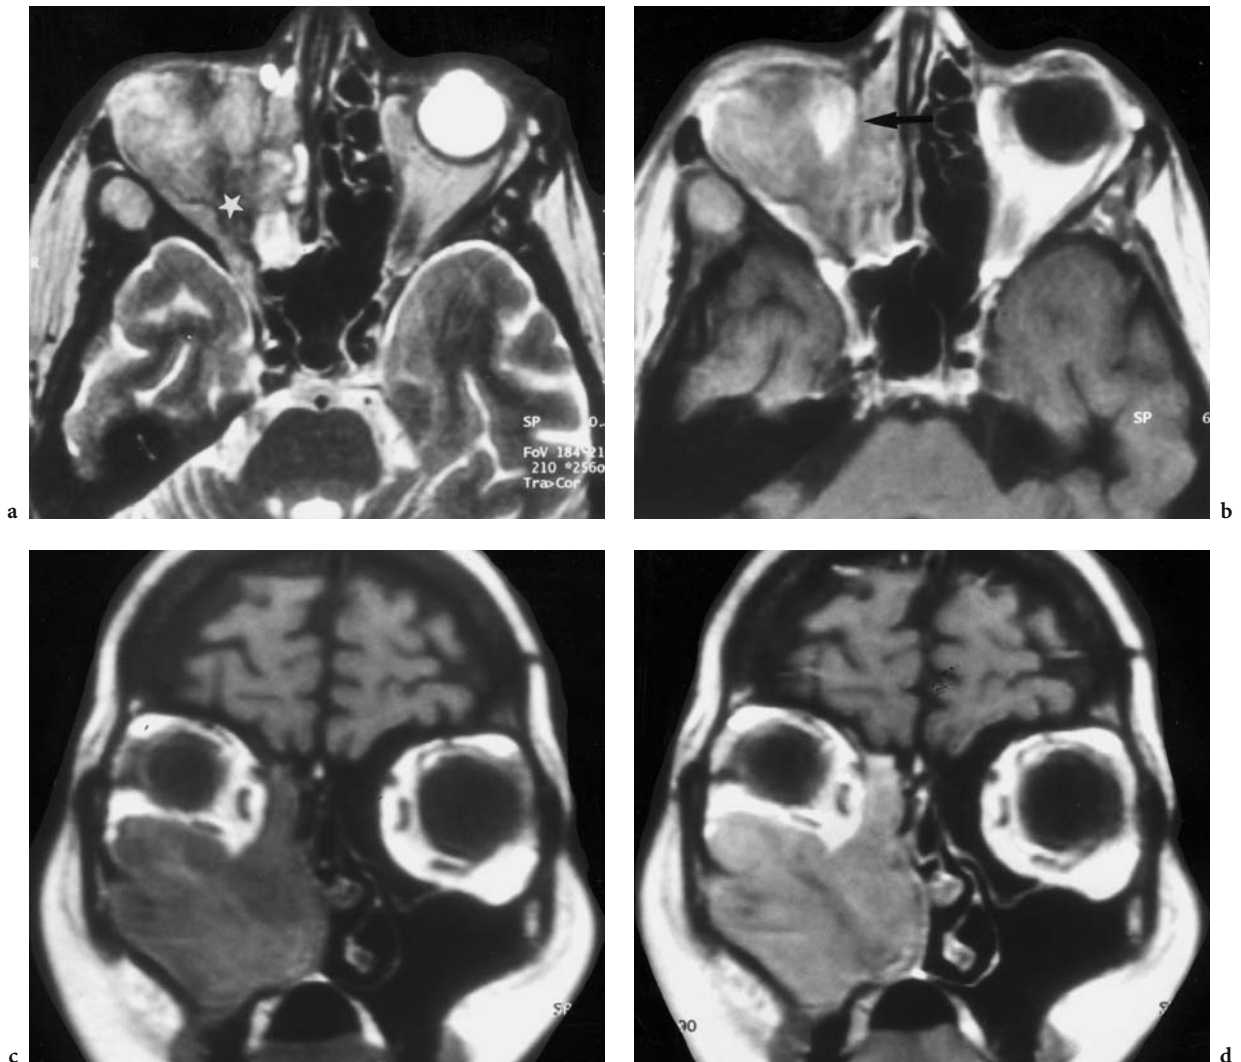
A 37-year-old woman with previously operated primary melanoma of the maxillary sinus, presenting with swelling of the right eye. Diagnosis: intraorbital expansion of the maxillary sinus melanoma. MR: a Axial T2-weighted view of the inferior orbit, filled with tumor on the right side leading to the suspicion of infiltration of the inferior rectus muscle (*white star*) and orbital fat. Note additional tumor invasion of the ipsilateral temporal fossa. The bright signal of the ethmoidal cells represents mucous retention. b Corresponding T1-weighted, contrast-enhanced view with slight, homogeneous enhancement of the tumor, but a nearly normal signal intensity for the fat (*arrow*) medial to the rectus muscle. c Coronal T1-weighted native view showing the entire tumor expansion in the right maxillary sinus, nasal cavity, and ethmoidal sinus, as well as inferior orbital invasion. Note the upward displacement without infiltration of the inferior rectus muscle and globe. d Corresponding T1-weighted, contrast-enhanced view showing nearly homogeneous enhancement
